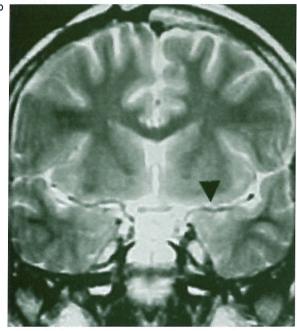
MR brain imaging 4 years after surgery and radiation at the time of clinical symptoms. Axial T2-weighted spin echo MR image at the level of the pineal gland and Axial T1-weighted spin echo MR image after intravenous gadolinium administration (A) showed disappearance of the germinoma. No evidence of tumor recurrence or CSF metastasis and no signal abnormality of brain parenchyma. Axial T2-weighted spin echo MR image (B) at circle of Willis and coronal T2-weighted spin echo MR image (C) showed fainting but signal void of the supraclinoid and left A1 (large arrowhead), M1 segments persist (small arrowhead).
